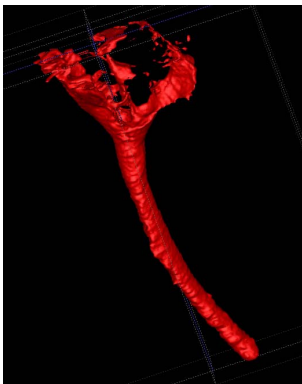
3D reconstruction of Patient's 1 geometry from the 3D MRI images
